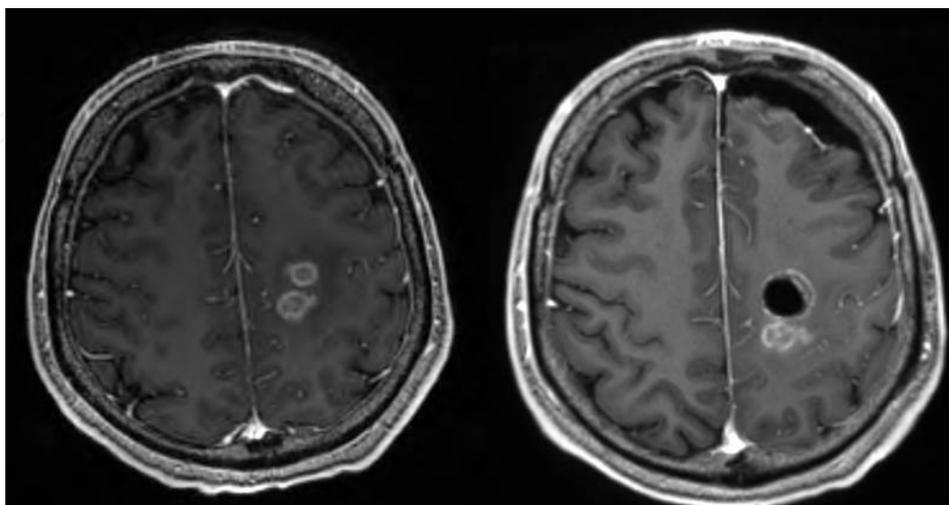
Preoperative and intraoperative axial T1-weighted post contrast scans; subcortical stimulation was positive along the lateral and posterior border of the resection cavity thus a portion of the tumor was not resected.
